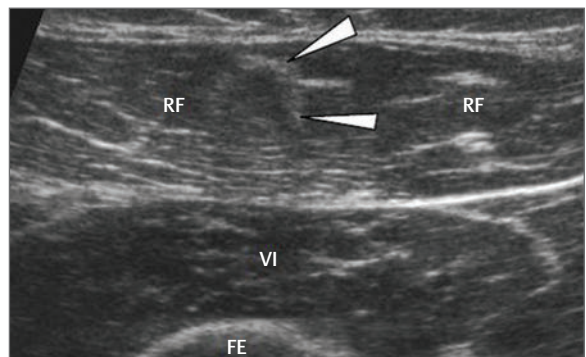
Ultrasound image of the anterior aspect of the midthigh. The rectus femoris (RF) muscle can be seen to overlay the muscle of vastus intermedius (VI). The central aponeurosis of rectus femoris (arrowheads) is a direct extension of the indirect tendon. The femur (FE) may be seen deep to the muscle of vastus intermedius.
